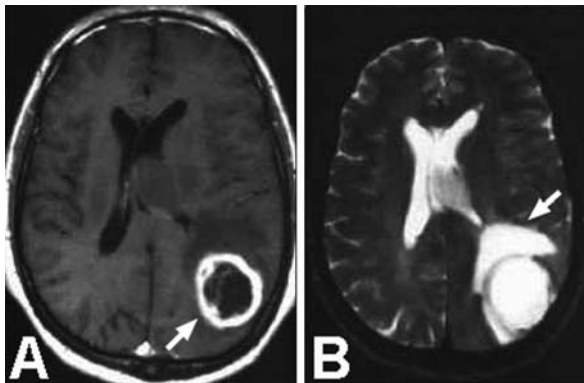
Glioblastoma (WHO grade IV) has a distinct growth pattern on magnetic resonance imaging (MRI). (A) Axial post-contrast MRI of GBM shows a ring-like pattern of contrast-enhancement (*arrow*) surrounding a central zone of necrosis. (B) Axial T2-weighted MRI demonstrates a hyperintense region (*arrow*) peripheral to the central necrotic zone, which represents diffusely infiltrating tumor cells and the accompanying vasogenic edema
